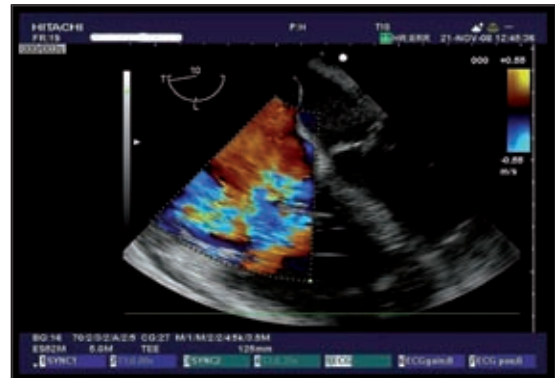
Cardiogenic shock: bedside doppler echocardiographic assessment.
